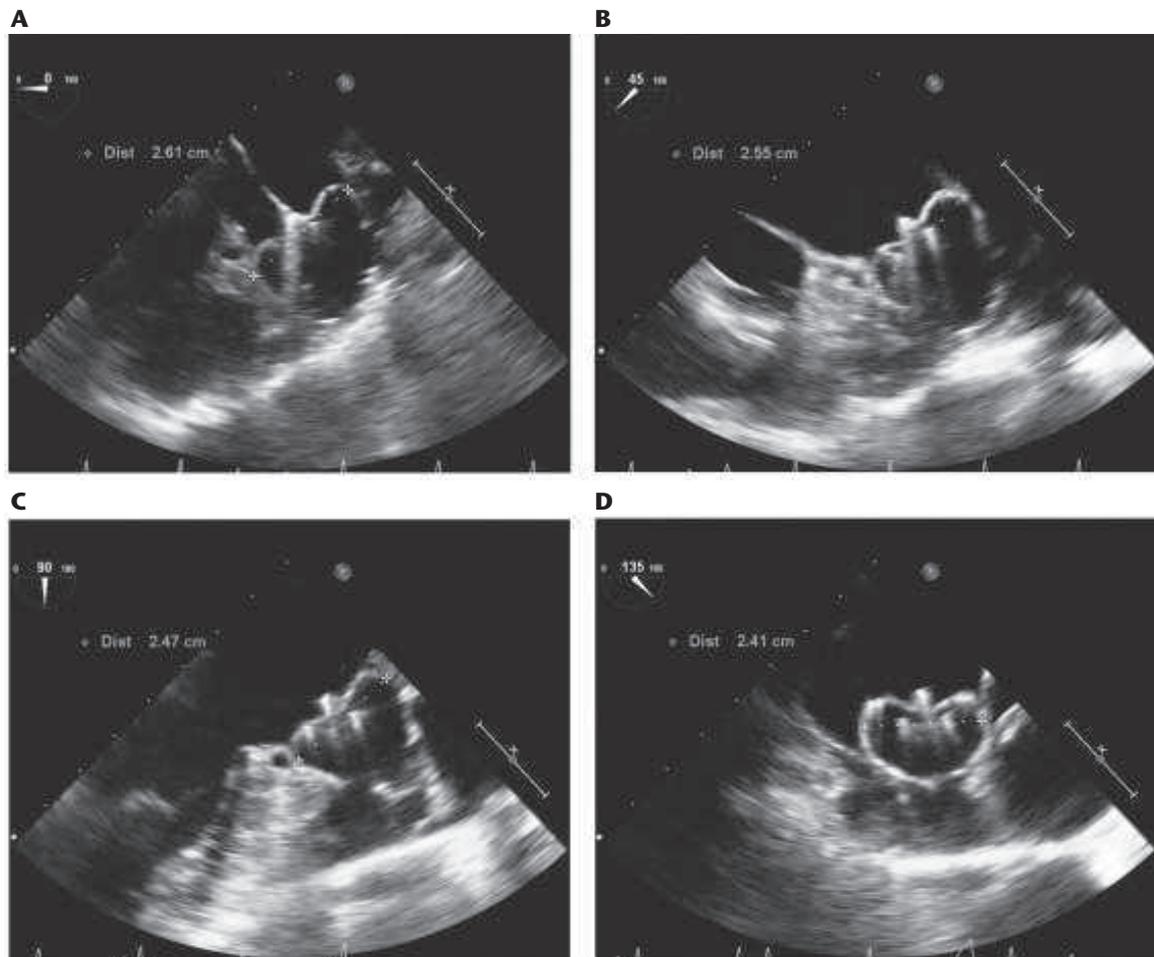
Postprocedural transesophageal echocardiographic (TEE) assessment of WATCHMAN™ implantation. After deployment, the device is assessed at 0°, 45°, 90°, and 135° (Panels A, B, C, and D, respectively). Compression is determined by measuring the distance across the shoulders of the device. If compression and position are adequate, the left atrial appendage sealed by color Doppler and fluoroscopy, and the device well anchored according to a “tug test,” the device is released. WATCHMAN™ is manufactured by Boston Scientific (Natick, MA).
